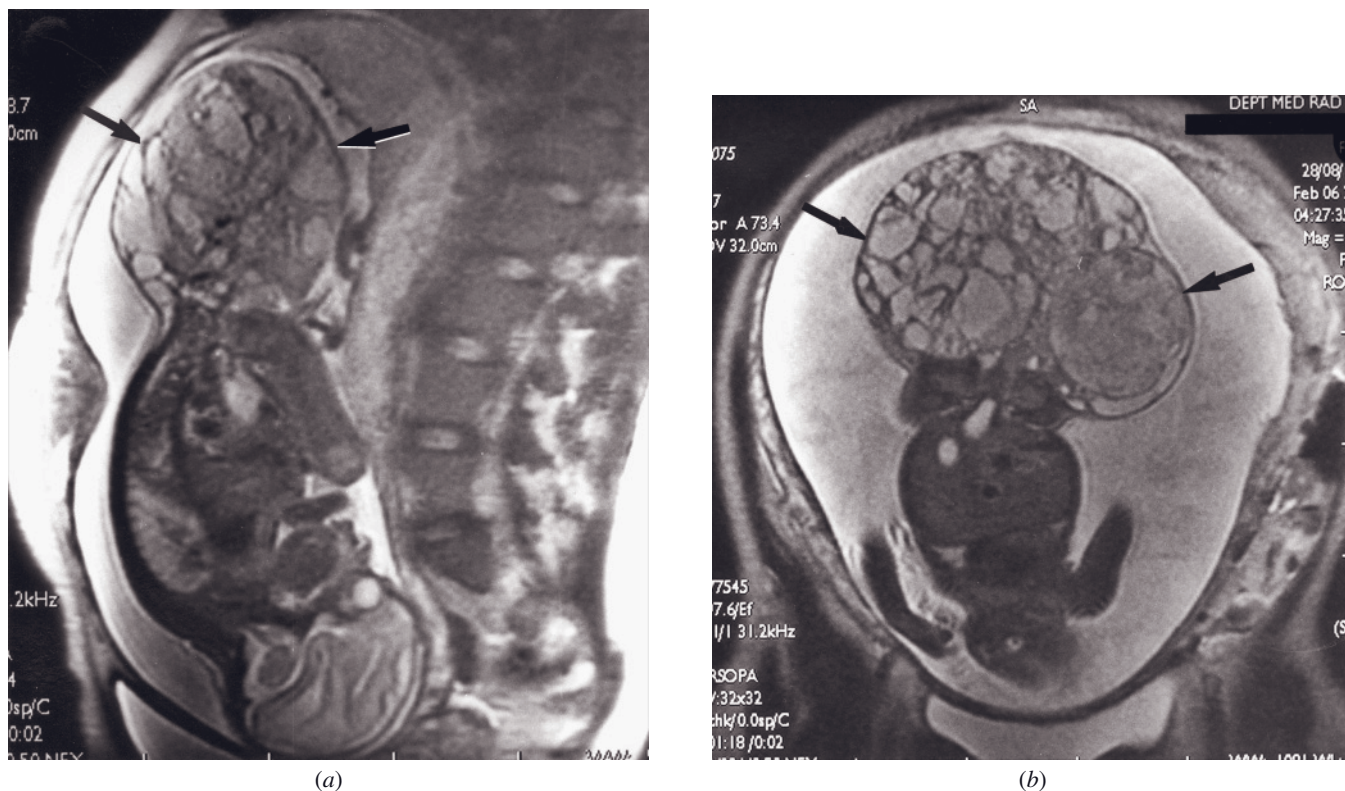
Fetus with sacrococcygeal teratoma at 28 weeks of gestation. Sagittal (a) and coronal (b) T2-weighted SS-ETSE images of the fetus show a large, mainly cystic, hyperintense lesion in the sacral region (arrows, a, b). Associated polyhydramnios is seen.
